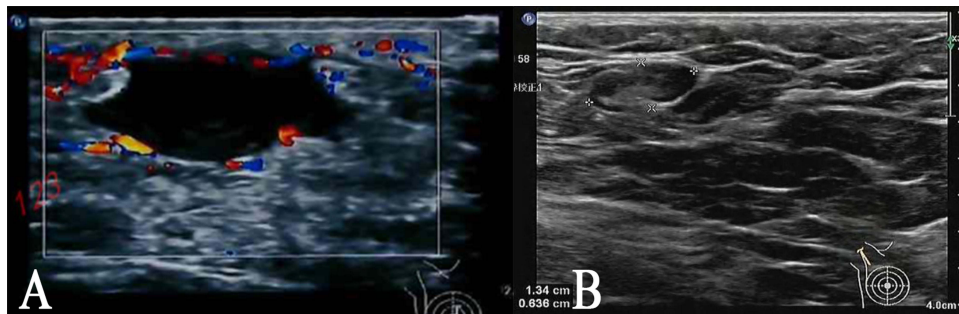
Ultrasound imaging of the right breast revealed an irregularly shaped and ill-defined hypoechoic mass, which measured 1.5×0.8 cm, with evidence of internal vascularization, located in the subareolar area (A). The existence of right axillary lymphadenopathy was identified through ultrasound examination (B).
